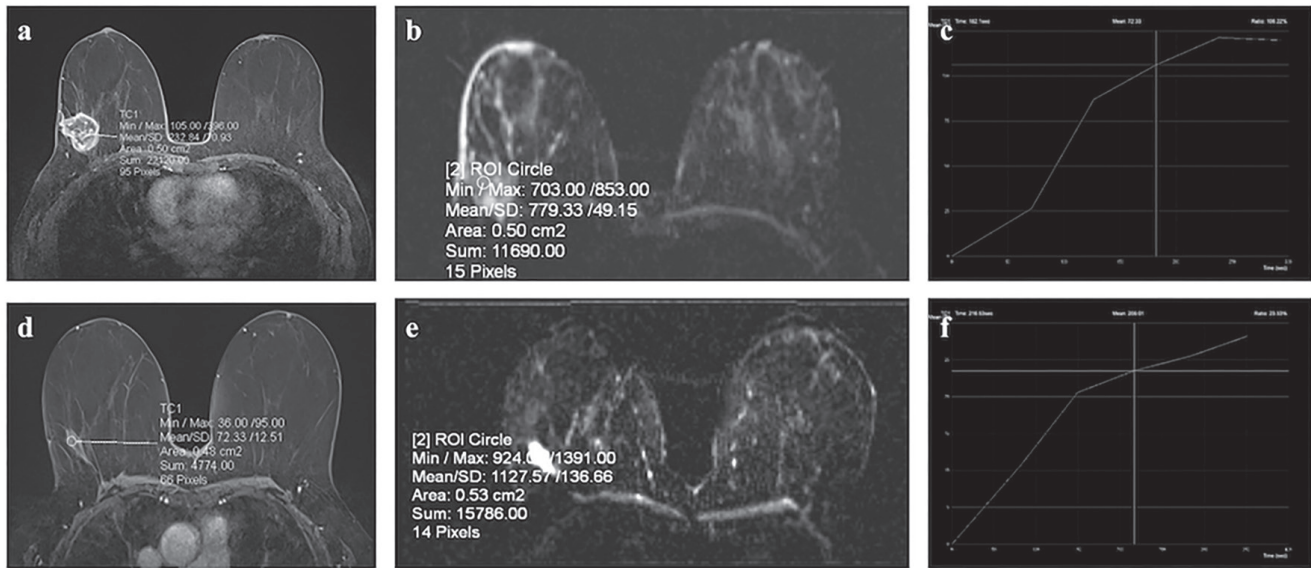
Pre- and mid-neoadjuvant chemotherapy (NAC) breast magnetic resonance imaging (MRI) of a 60-year-old woman with clinical stage cT2N1 triple-negative invasive ductal carcinoma who demonstrated a partial pathological response at the end of treatment, (a) axial post-contrast T1-weighted (T1W) image, (b) apparent diffusion coefficient (ADC) map, and (c) time-intensity curve (TIC) with calculated Epeak from the pre-NAC MRI, (d) axial post-contrast T1W image, (e) ADC map, and (f) TIC with Epeak from the mid-NAC MRI
